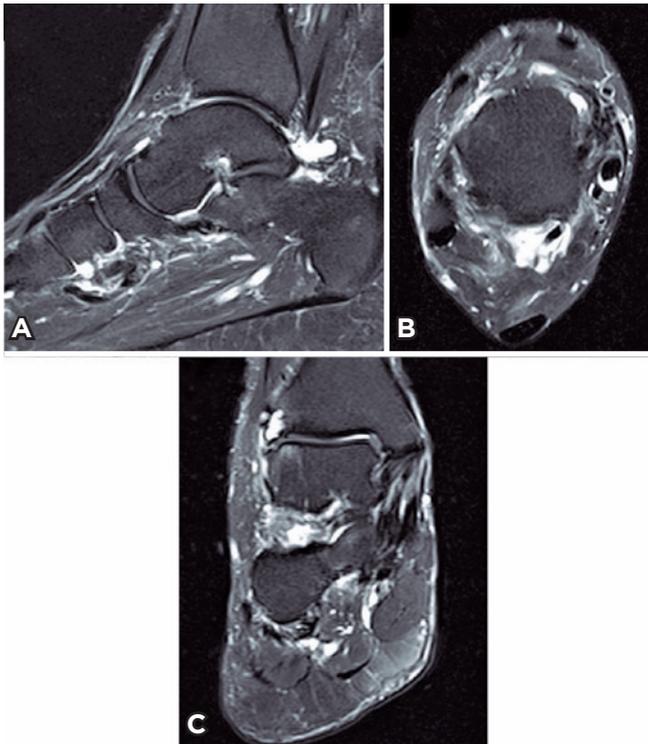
MRI showing spring (A), posterior tibial tendon (B) and deltoid (C) integrity.
